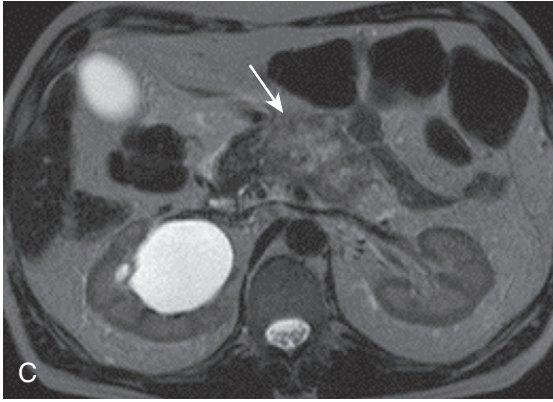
Pancreatic adenocarcinoma—the double duct sign. A, The MRCP image shows marked biliary (*closed arrows*) and pancreatic (*arrowheads*) dilatation, abruptly terminating at the level of the pancreatic head, where there is a cystic lesion (*open arrow*). The fat-suppressed T2-weighted (B) and postcontrast (C) images reveal the obstructing pancreatic head mass (*arrow*) with central necrosis, accounting for the cystic lesion on the MRCP image.
